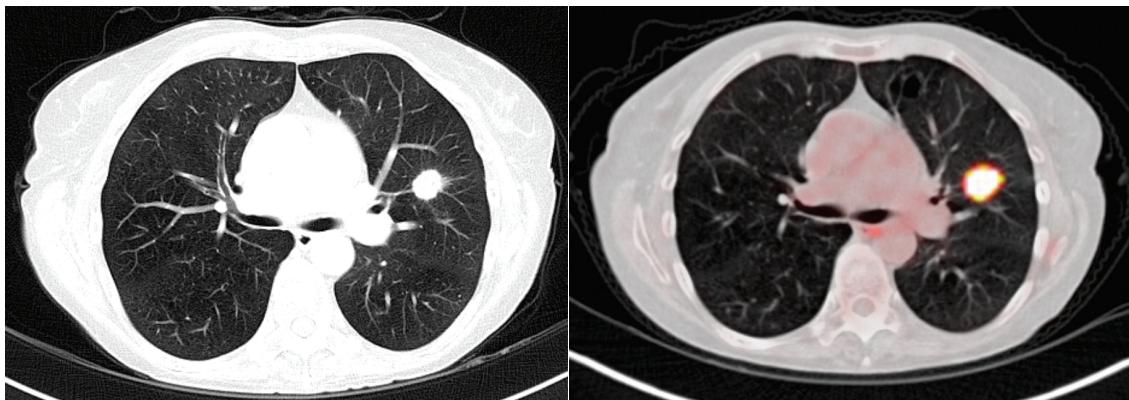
CT-scan of the chest showing a nodule of the left upper lobe with spiculation 17 x 16 mm (left panel). The correlated PET image shows profound FDG-uptake by the left upper lobe lesion (right panel). The subject was diagnosed with a cT1aNOMO non-small cell lung cancer.
